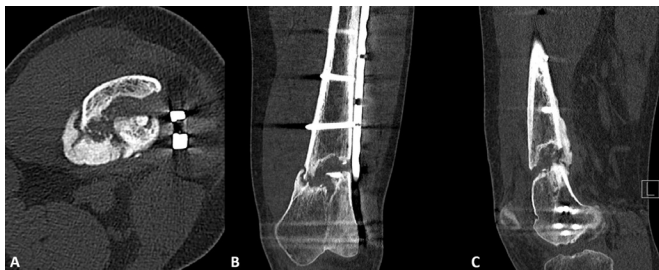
CT images of the left distal femur at 9 months postoperatively. There was a thin column of callus formation to the posterior aspect of the distal femoral fracture. There was no evidence of union across the fracture, identified with sclerotic margins consistent with an established non-union. (A) Axial view. (B) Coronal view. (C) Sagittal view.
